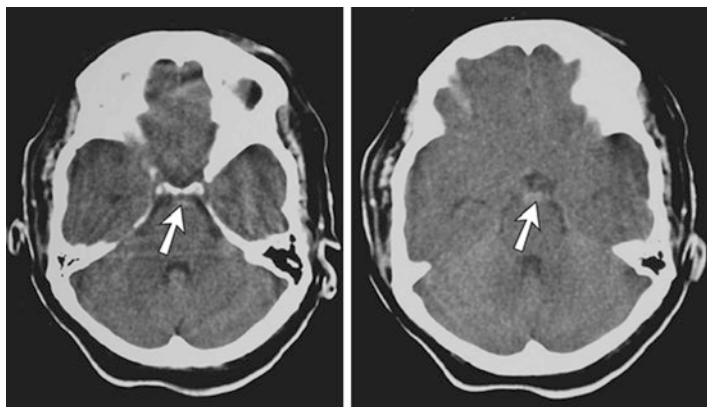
Shows the CT scan of a 51-year-old hypertensive and diabetic lady with sudden onset severe headache described as the worst headache of her life. She was alert but had neck stiffness and mild photophobia. The small hemorrhage in front of the pons could easily be overlooked unless this area is scrutinized. That it is not an artifact is confirmed by tracing its continuity on contiguous slices. *It is far safer to err on the cautious side and have a more experienced person review the images should you see these appearances on only one slice or suspect they are artifacts!*
